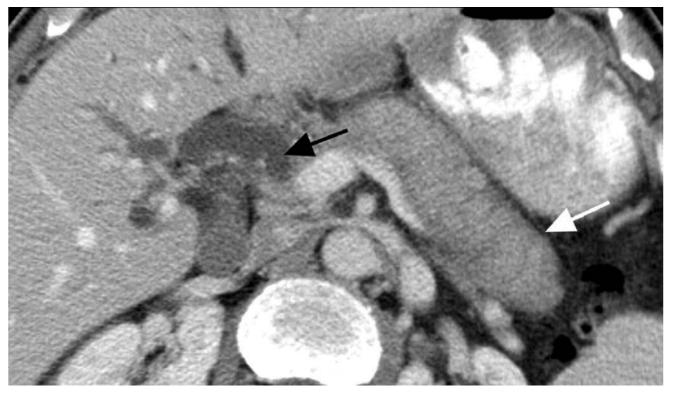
Axial CT scans of the abdomen
